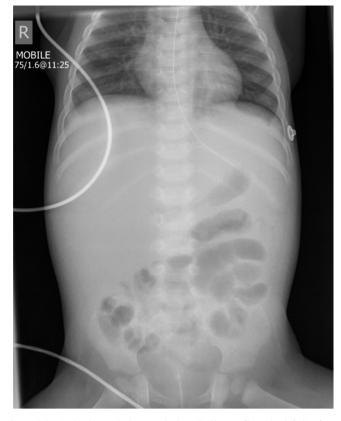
Abdominal radiograph showing thick-walled loops of bowel in left iliac fossa.
